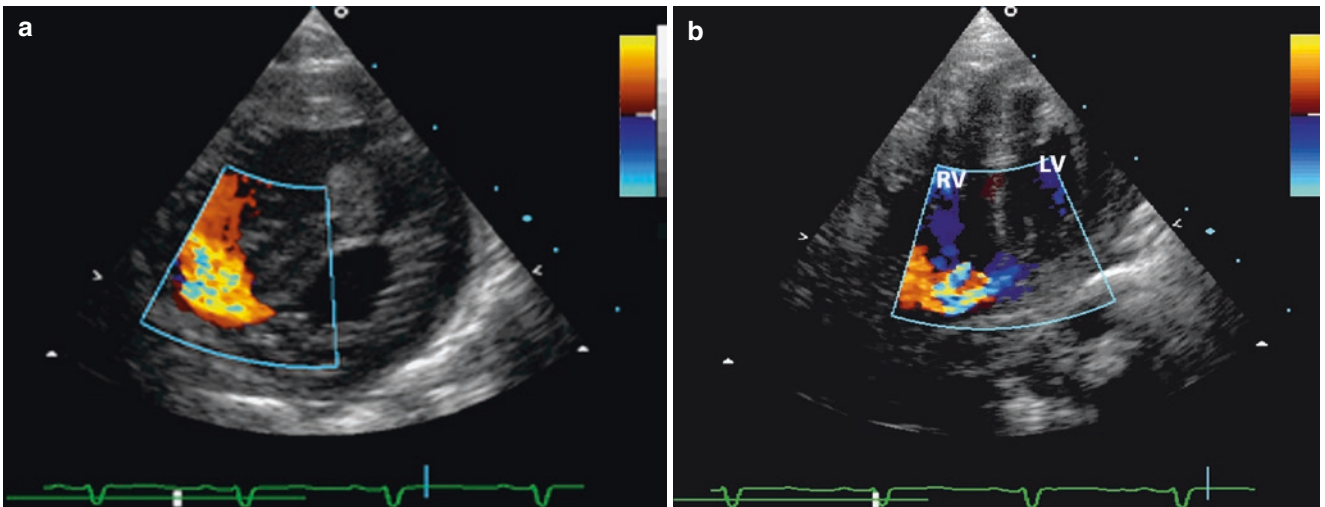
Colour Doppler examination in the parasternal short-axis view showing a muscular inlet VSD (a). Visualization of the defect in the four-chamber view requires a posterior orientation of the transducer (b). *LV* left ventricle, *RV* right ventricle
